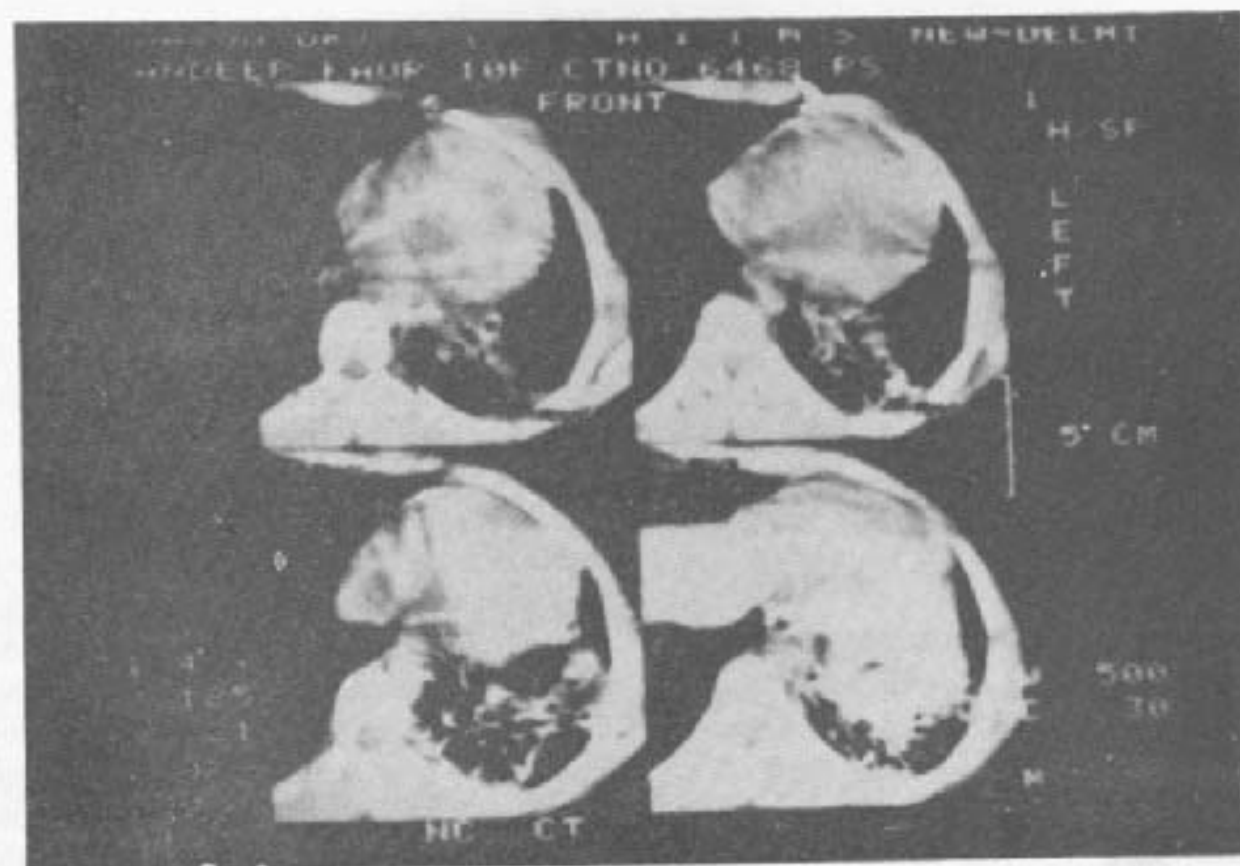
CT scan of chest showing cystic bronchiectasis of left lower lobe.
